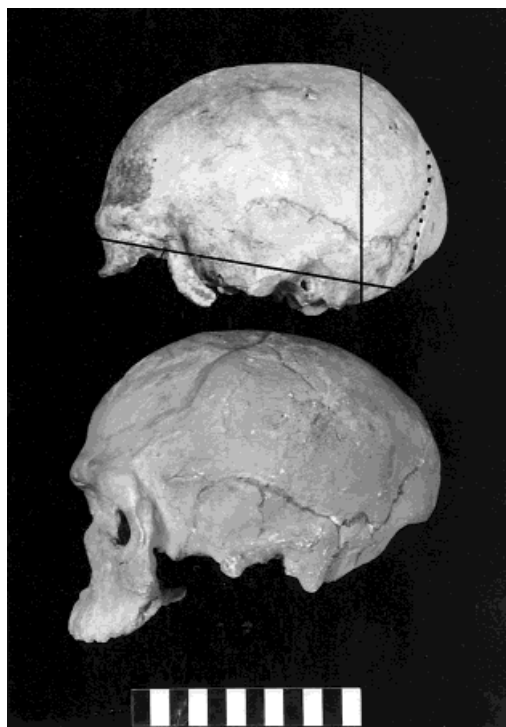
Left lateral view of the Singa calvaria (top) in comparison with a cast of the Jebel Irhoud 1 cranium (bottom). The transverse and coronal planes of the CT scans of Singa, given in Figs. 2 and 3, are indicated by solid lines and the fracture posterior to the parietal bosses by the dotted line. Scale, 12 cm.
